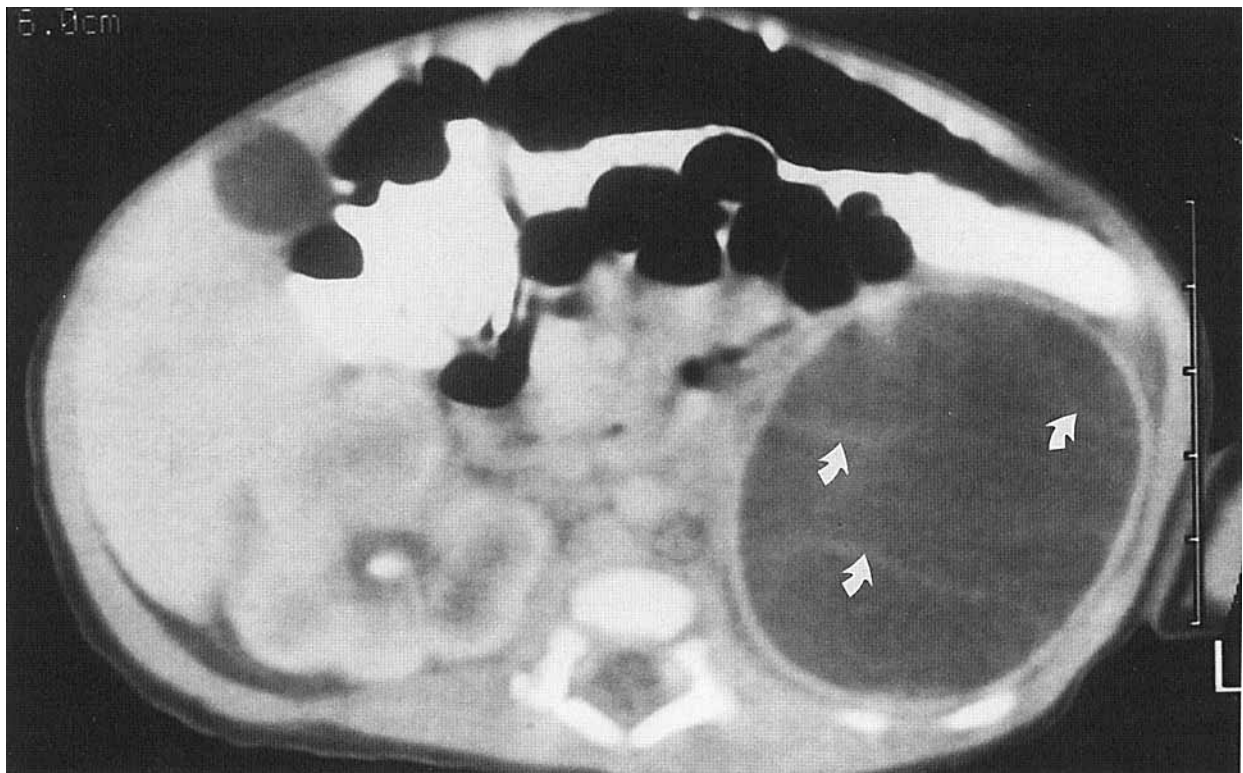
Postnatal CT. A predominantly cystic mass is seen in the left upper abdomen. A discernible wall and faint internal septations (arrows) are noted.
